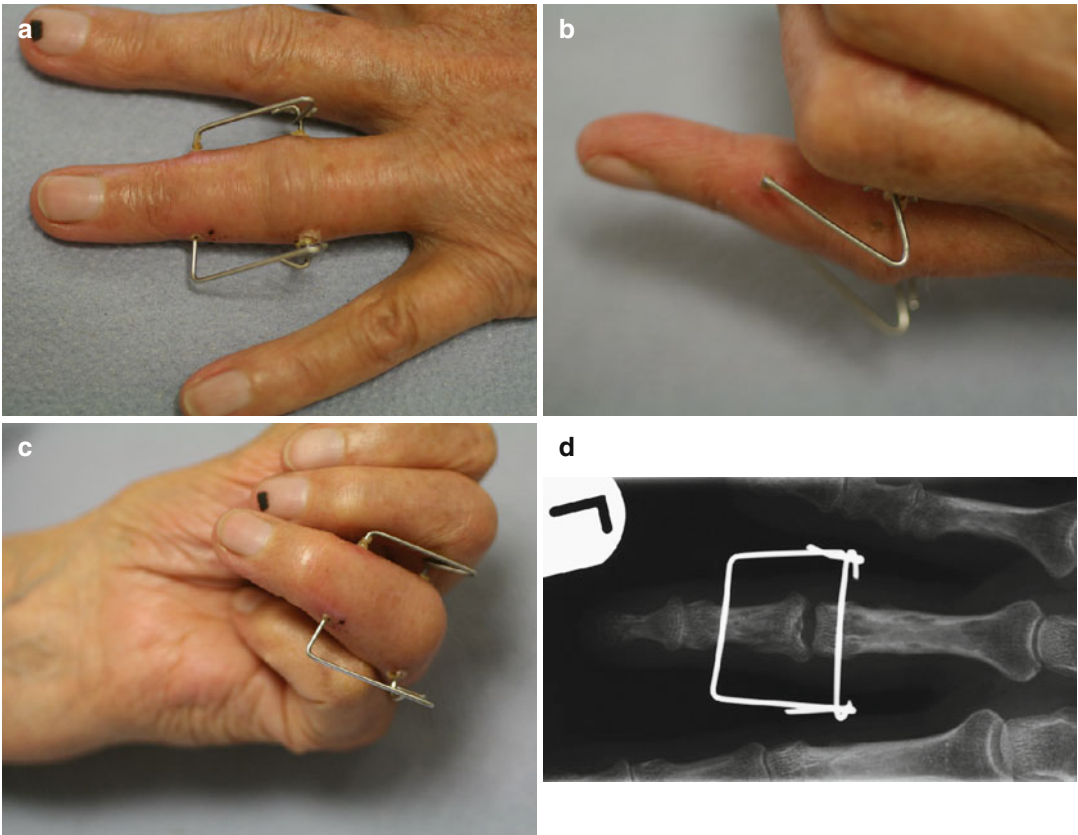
Clinical photographs and a radiograph of a K wire dynamic external fixator. (a, b, c) Clinical images, (d) x-ray appearance
